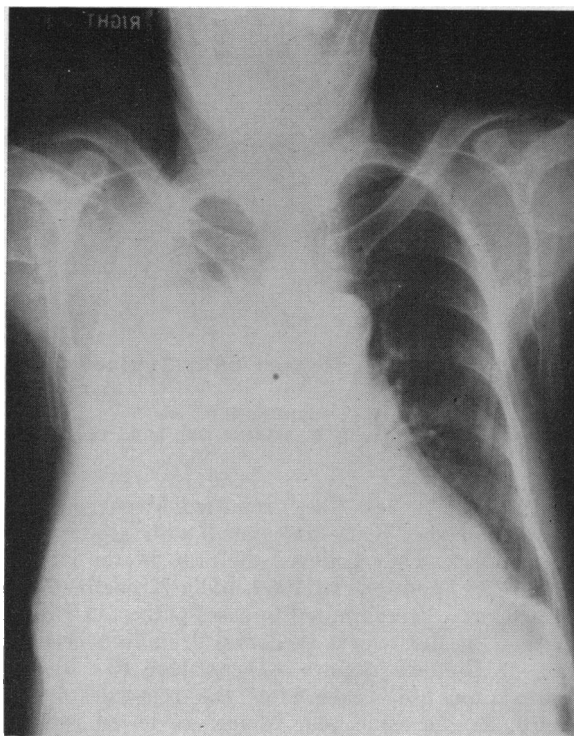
Roentgenogram showing opacification of the right hemithorax by pleural fluid.
